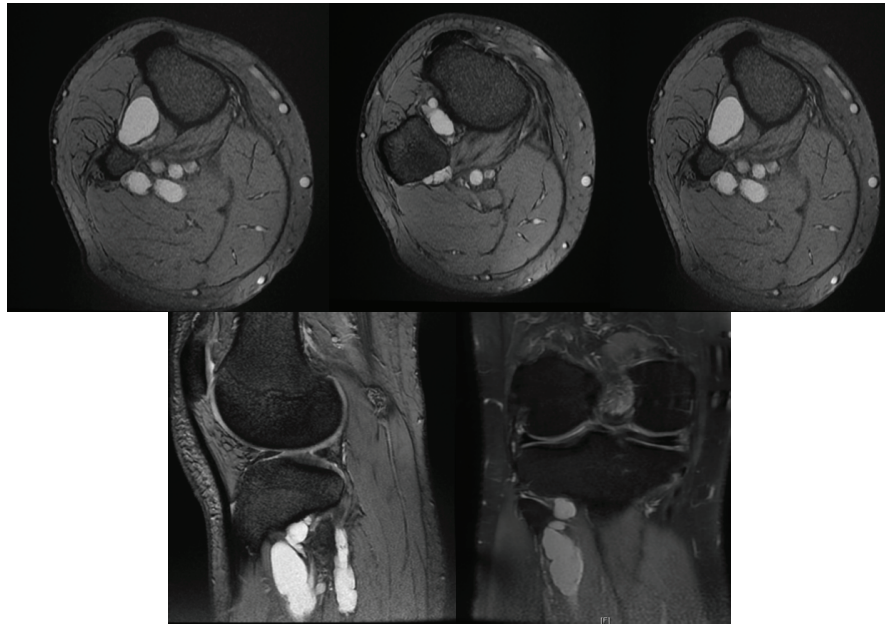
MRI images of the right knee showing large lobulated cystic lesion seen at the level of proximal tibiofibular joint with intramuscular and intermuscular components. In coronal images, it measured about 5.2×1.8 cm.
